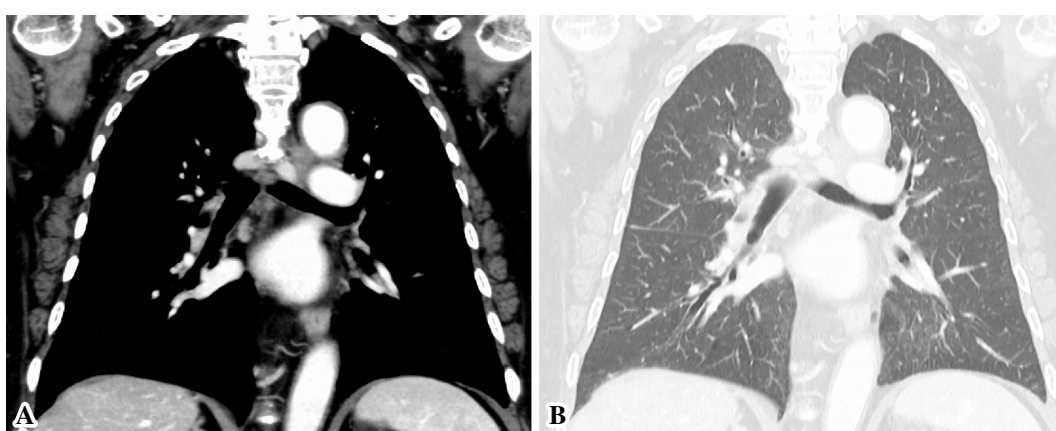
A, B: Chest contrast-enhanced CT on day 73 showing that the swollen connective tissue around the right bronchus had disappeared.
